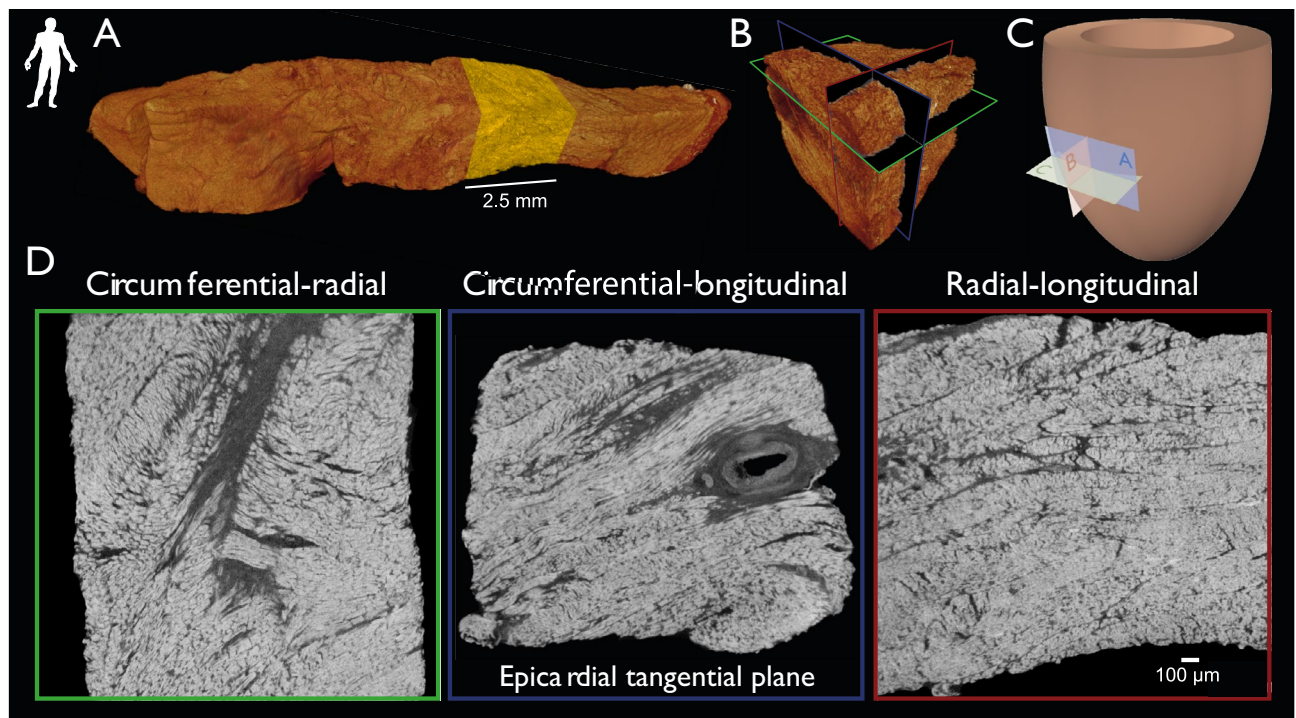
Global reference planes: Panel (A) High-resolution X-ray microtomography of a transmural human heart biopsy. A subset (yellow) is selected for virtual orthogonal transection (Panel B). Panel (C) The global orthogonal planes are shown with reference to the left ventricular myocardium. Resulting orthogonal views are shown below in Panel (D). Each orientation is colour-coded as green for the circumferential-radial plane, blue for the circumferential-longitudinal plane, often referred to as the epicardial tangential plane, and red for the radial-longitudinal plane. The colour-coding is maintained for the remainder of the figures.
